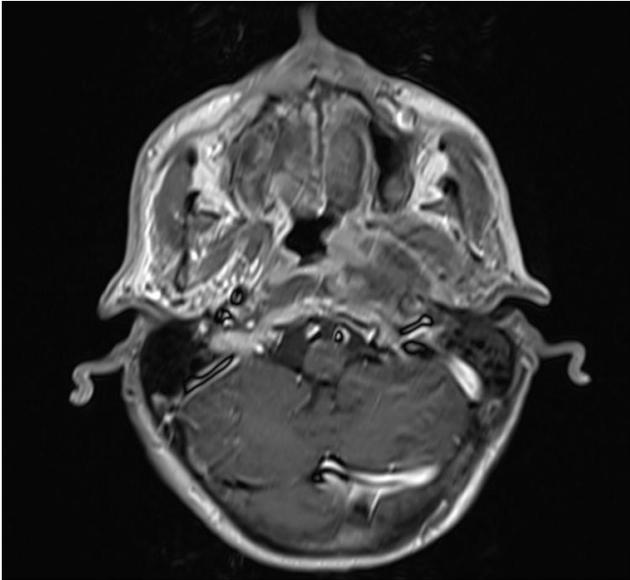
Asymmetry of the nasopharynx in the MRI image.
